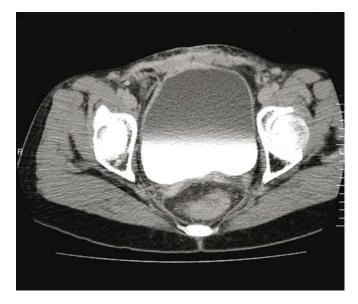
CT cystogram done 3 months later does not show any leak
